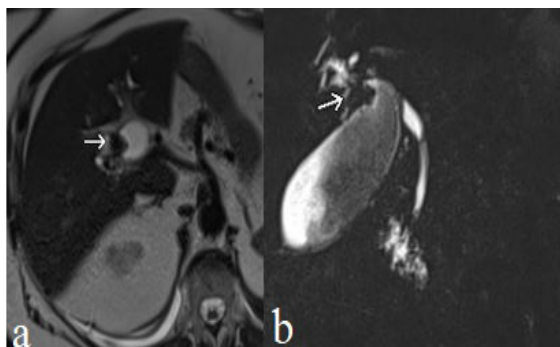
A female patient with Mirizzi syndrome, 45 years old. A T2-weighted axial scan (a) reveals a hypointense gallstone within the cystic duct. The impact of the gallbladder stone on the intrahepatic bile ducts and bile duct dilatation is evident in the MRCP image (b). The calibration of the common bile duct is within normal ranges.
